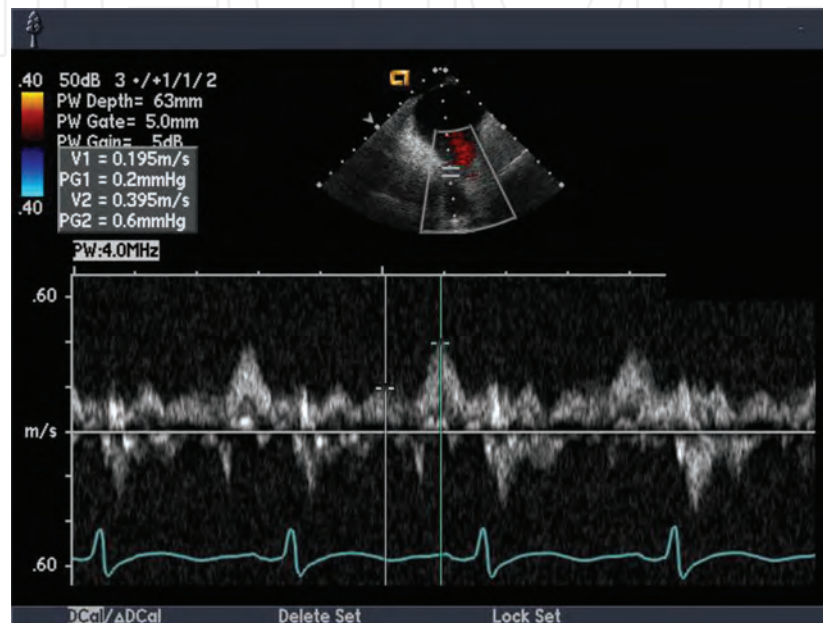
Continuous wave Doppler of the pulmonary veins.
